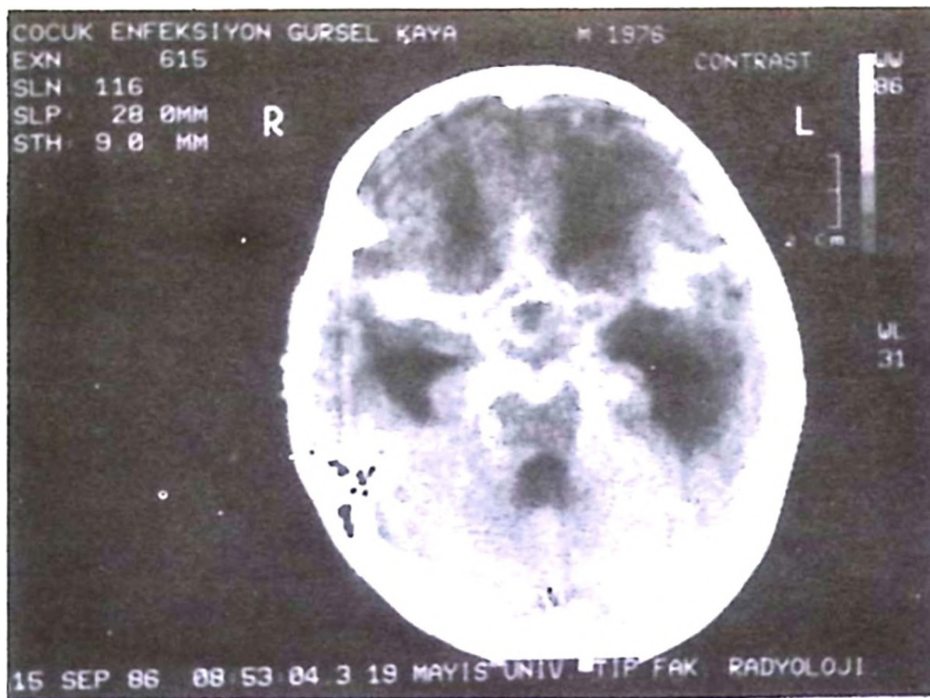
Postcontrast CT study of Case No. 3 at the same level with Fig. 1 demonstrates abnormal enhancement in cisterns around the brainstem and the base of the brain.
